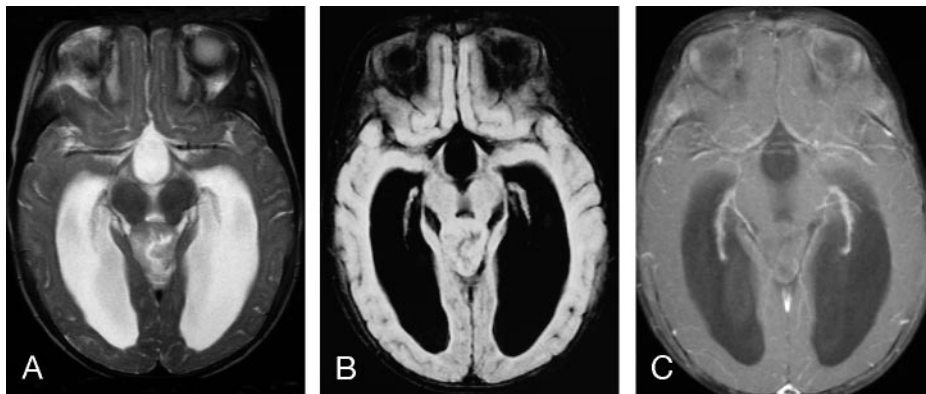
MR images of an 8-month-old female infant with AT/RT involving the pineal gland
